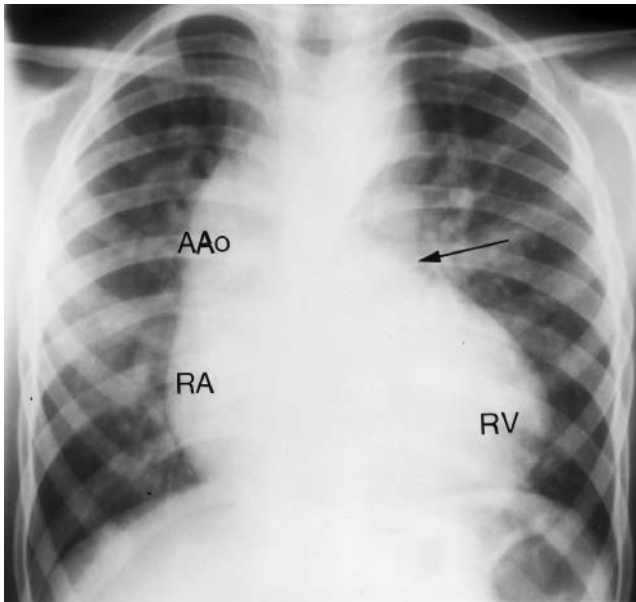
X-ray from a three-year-old male with tetralogy of Fallot and pulmonary atresia. Pulmonary vascularity is bilaterally increased because of direct arterial collaterals that arose from the descending thoracic aorta and had hilar anastomoses. The main pulmonary artery is not border forming (arrow), but the ascending aorta (AAo) is conspicuously dilated. A convex right atrium (RA) occupies the right lower cardiac silhouette, and the apex is occupied by a convex right ventricle (RV).
